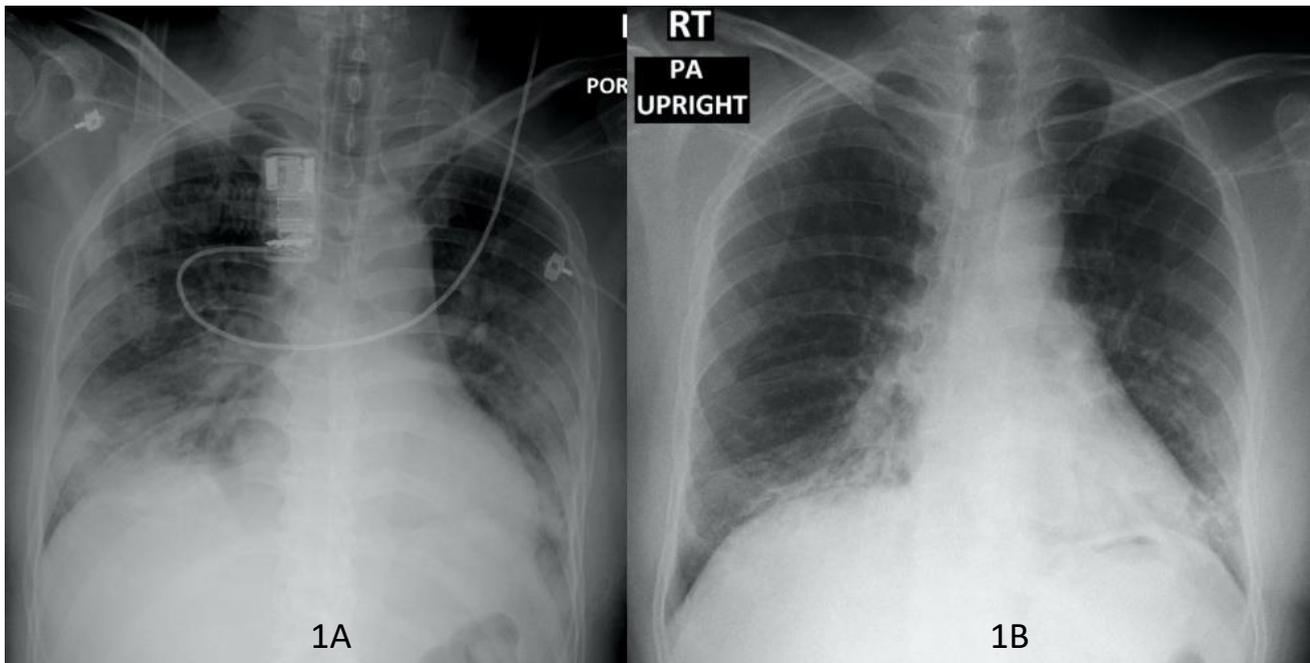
Chest x-rays(CXR): 1A CXR of the patient on admission (before convalescent plasma transfusion), 1B CXR of the patient on day 5th after convalescent plasma transfusion.
